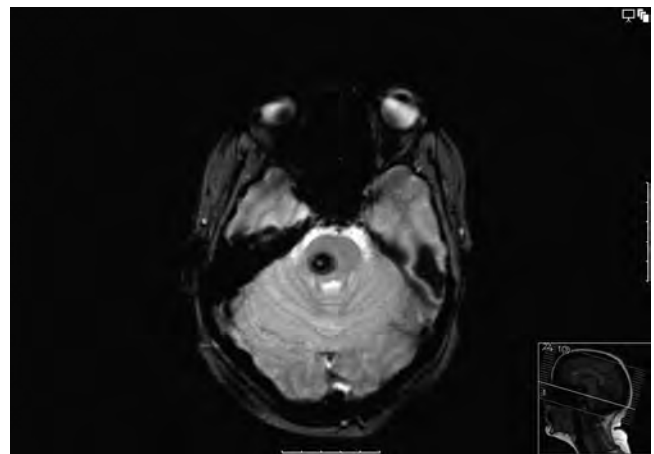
MRI Gradient Echo image showing pontine CCM with haemorrhage.
